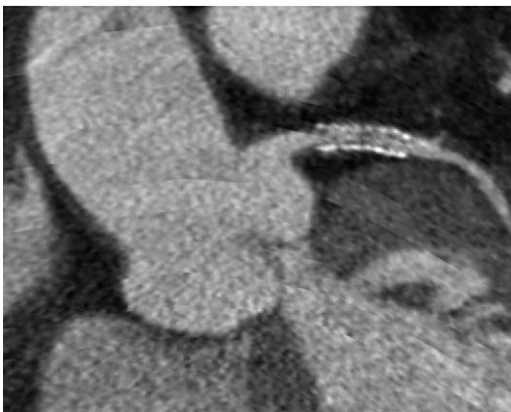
Cardiac imaging using a multisector reconstruction approach. The image shows restenosis in a stent placed in the proximal left anterior descending coronary artery. Data were acquired with a clinical CT scanner configured with 0.625 mm slice thickness (GE Lightspeed 16) and reconstructed with a multisector approach at 0.3 mm intervals with overlapping slices. Using state-of-the-art CT imaging technology and multisector reconstruction algorithms, today's scanners have capabilities that approach the spatial resolution and the temporal resolution needed to evaluate the coronary arteries of the heart. The heart rate of this patient during this examination ranged between 71 beats per minute and 82 beats per minute. (Courtesy of J.L. Sablarolles, MD, Centre Cardiologique Du Nord, Saint Denis, France.)
